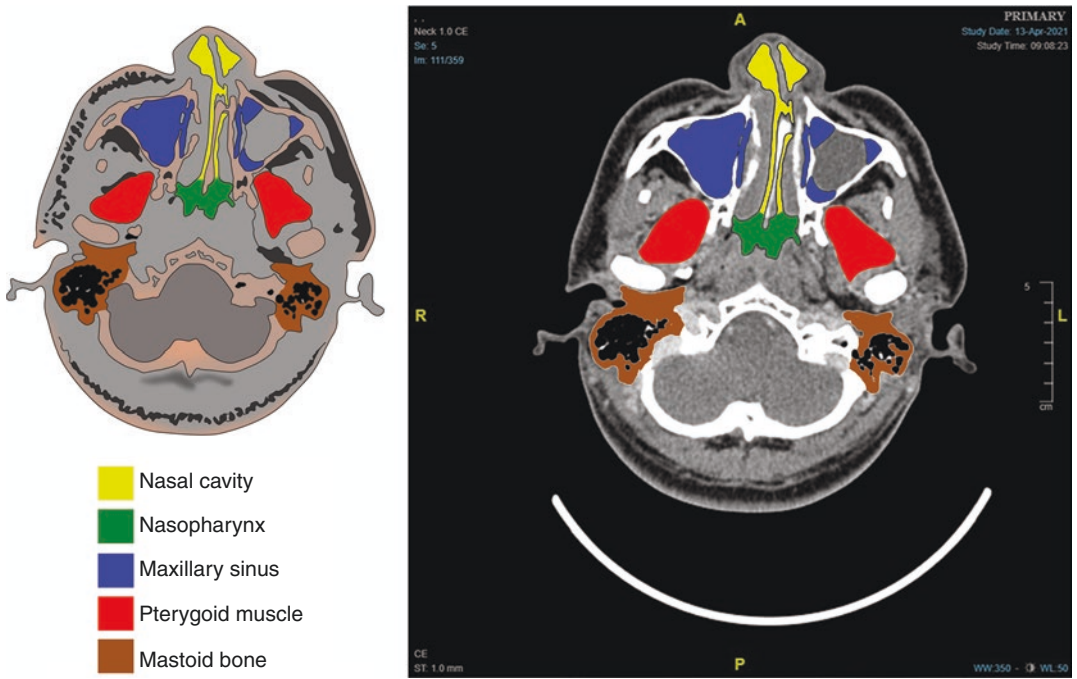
Identification of the structures visualized in the CT scan images such as nasopharynx, pterygoid muscle, maxillary sinus, nasal cavity, mastoid air cells, and adjacent critical structures is vital for preoperative surgical mapping
